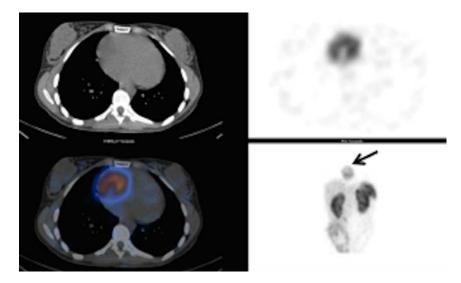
An ¹¹¹Indium-Octreoscan SPECT/CT showing focal intense increased uptake by the mass.
